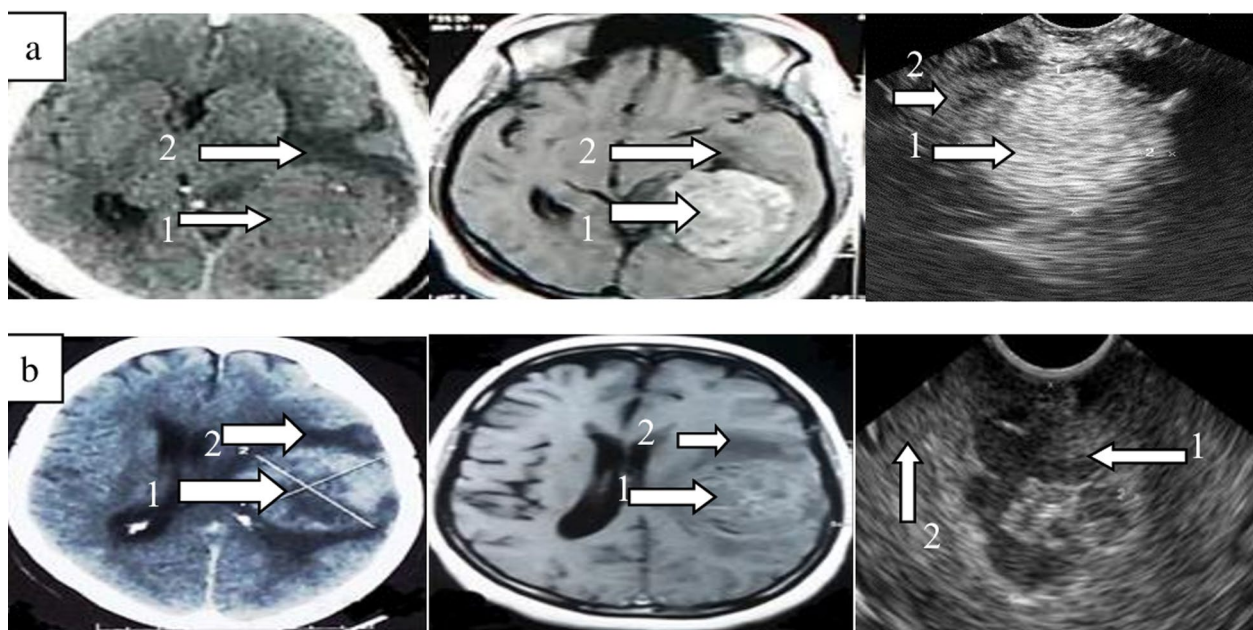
Imaging of meningioma by CT with contrast, MRI with contrast and IOUS. Arrows 1 refer to the fleshy tumor and arrows 2 refer to brain edema. Case a: Ill-defined mass without enhancement in CT and well defined with homogenous enhancement in MRI. Well-defined fleshy mass with homogenous hyper-echogenicity in IOUS. Case b: Well-defined fleshy mass with heterogeneous enhancement and necrosis in CT and MRI. Well-defined fleshy mass with hyper-echogenic periphery and hypo-echogenic center in IOUS. The ultrasound criteria of low-grades tumors as noted in case a are regular contours, hyper-echogenicity, homogeneity, and few amount of brain edema. The ultrasound criteria of high-grades tumors as noted in case b are irregular contours, necrosis, brain edema, hypo-echogenicity, and heterogeneity
